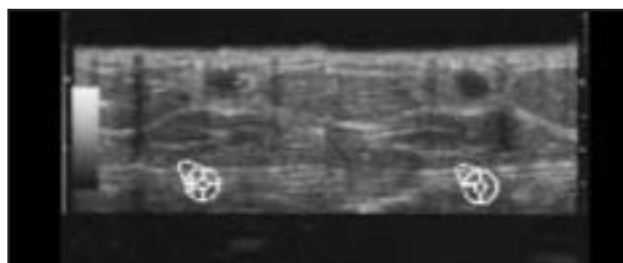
Selected image from breast ultrasound revealing subcentimeter, hypoechoic, solid masses corresponding to those seen mammographically.
